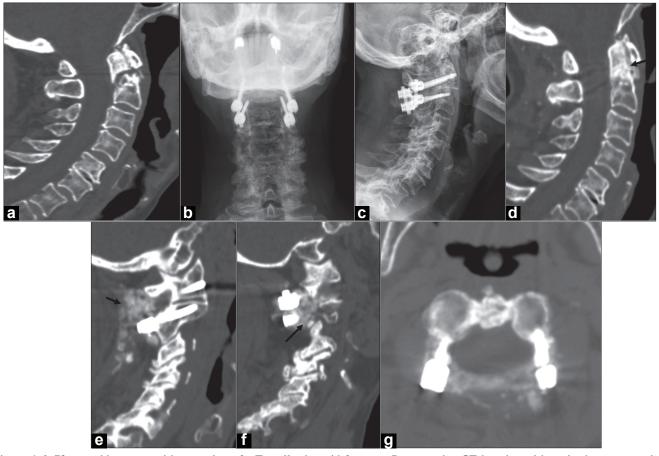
A 78-year-old woman with nonunion of a Type II odontoid fracture. Preoperative CT imaging with sagittal reconstruction demonstrates a Type II odontoid fracture (panel a). Postoperative plain AP (panel b) and lateral (panel c) radiographs following CI-C2 instrumented arthrodesis with CI lateral mass and C2 pedicle screws, rhBMP-2 and cancellous allograft. CT imaging with sagittal reconstructions at one-year follow-up demonstrates healing of the odonoid fracture (panel d, arrow) and brisk bony fusion (panels E and f, arrows). Axial CT imaging at the interspace of CI-C2 does not demonstrate canal encroachment (panel g).
